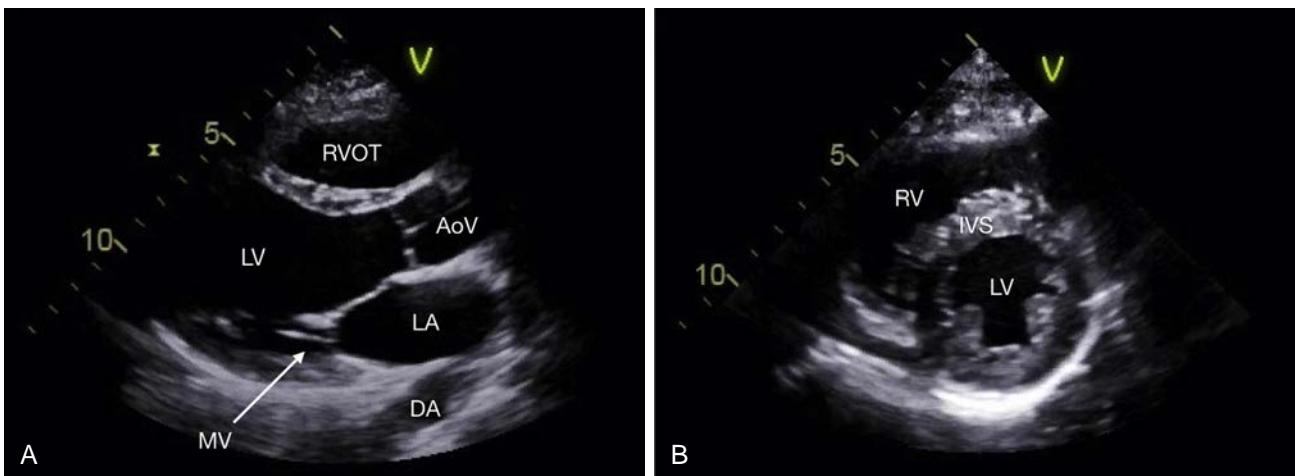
Transthoracic parasternal views included in focused cardiac ultrasound. (A) The parasternal long axis view is shown. This view is analogous to the transesophageal midesophageal long axis view. In transthoracic imaging, anterior structures are closest to the transducer (and therefore displayed at the top of the image), while in transesophageal imaging, posterior structures are in closest proximity to the transducer (and displayed at the top of the image). (B) The parasternal short axis view is shown. This view is analogous to the transesophageal transgastric mid-papillary short axis view. AoV, Aortic valve; DA, descending aorta; IVS, interventricular septum; LA, left atrium; LV, left ventricle; MV, mitral valve; RV, right ventricle; RVOT, right ventricular outflow tract.
